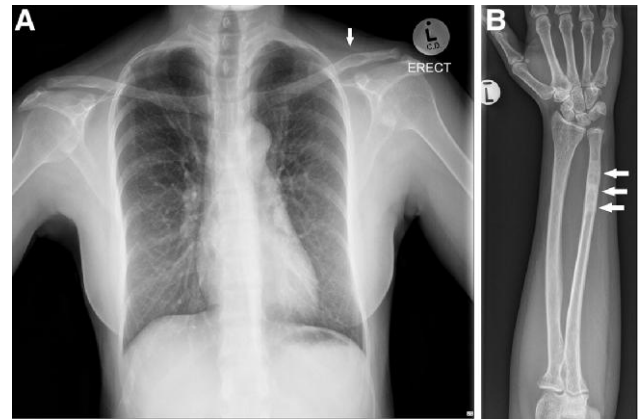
(A) Chest radiograph demonstrating a single lytic lesion in the distal one-third of the left clavicle; (B) X-ray of the left forearm showing multiple lytic lesions of the distal radius.
